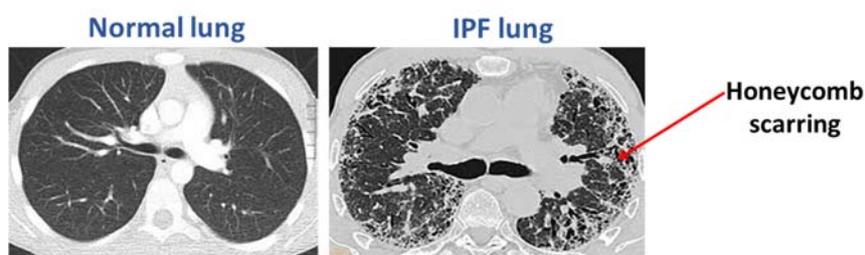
Images from CT scan of normal lungs and lungs from a patient with IPF. In the normal lung (left), the black image indicates healthy tissue, filled with air. In the IPF lung (right), scarring forms a typical ‘honeycomb’ pattern, showing fibrotic areas and restricted lung capacity.
